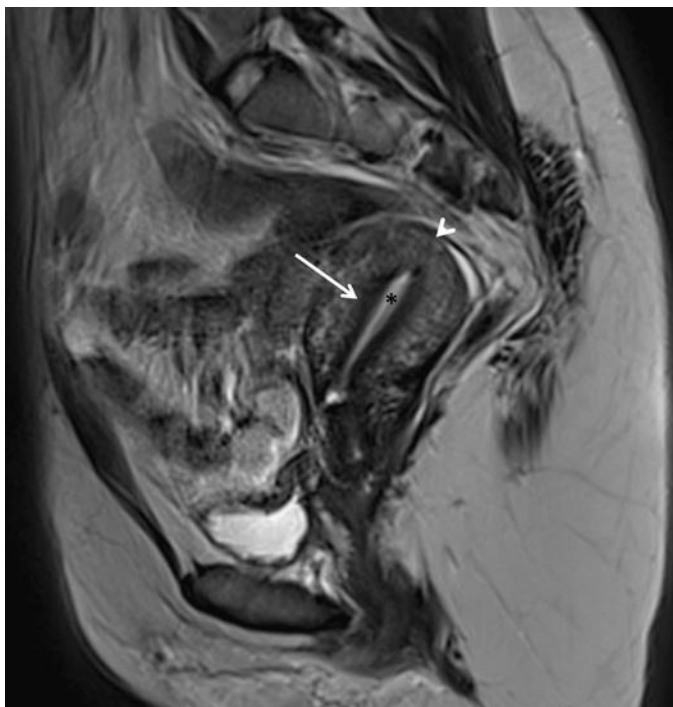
Normal uterus. Sagittal T2-weighted image demonstrating the high signal intensity of the endometrium (*asterisk*) and the zonal anatomy of the uterus, characterized by the low signal intensity (*dark*) junctional zone (*arrow*) subjacent to the endometrium and the intermediate signal intensity outer myometrium (*arrowhead*).
